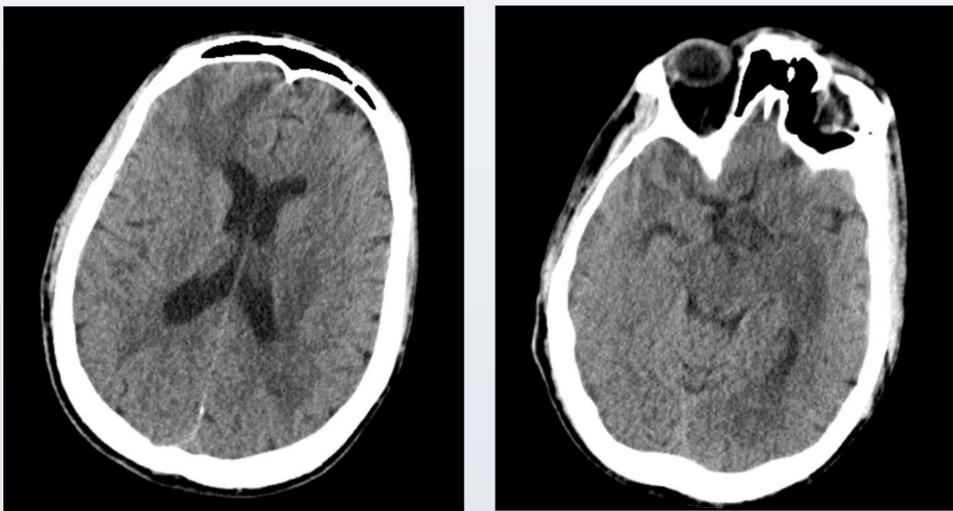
A (left) and B (right): Non-enhanced axial CT of the head demonstrates multiple hypoattenuating intra-axial lesions throughout the brain parenchyma. The gray-white matter differentiation is largely preserved and there is mild mass effect.
